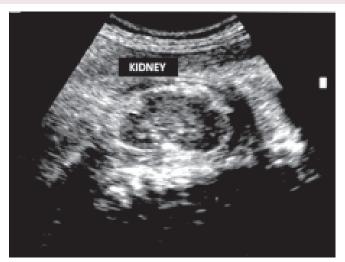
2D ultrasound image showing fetal kidney
